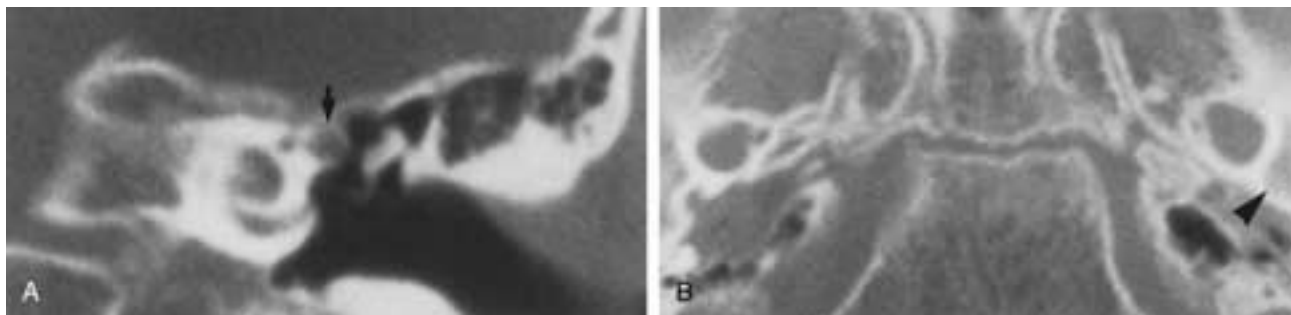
Persistent stapedial artery. A, B, High-resolution CT. The artery in the tympanic cavity through the stapes is not visualized, but the anterior portion of the tympanic segment of the facial nerve canal is enlarged (arrow) and the ipsilateral foramen spinosum is absent (arrowhead). (Courtesy of Dr. David Sobel.)
